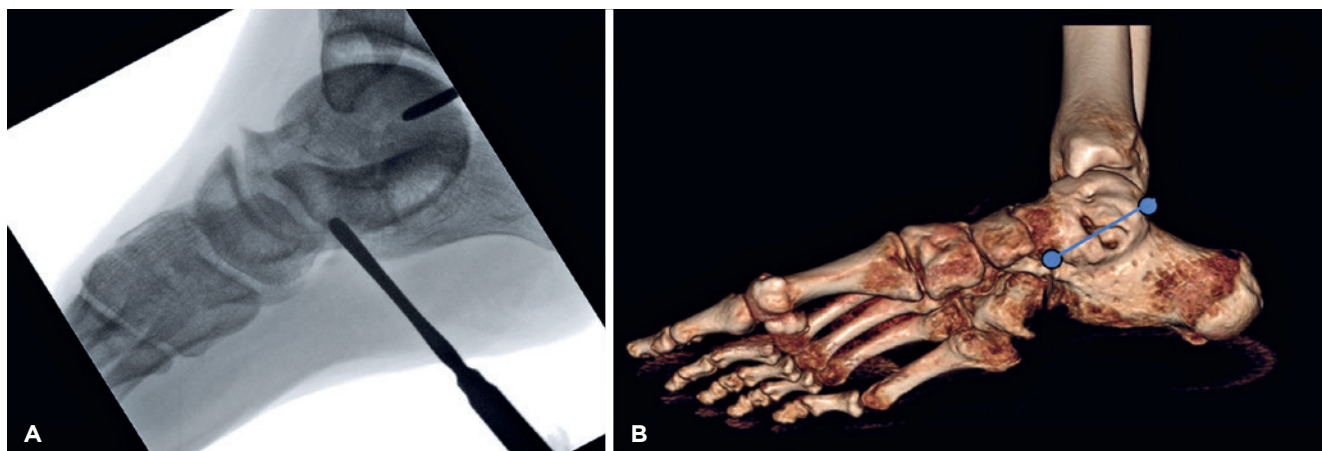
Technical tip. (A) Two Freer elevators are inserted under direct visualization to guide the orientation of the osteotomy: one in the posterolateral patent aspect of the posterior facet of the subtalar joint and one underneath the talar neck. (B) 3D Weightbearing CT bony reconstruction showing the dots representing the tip of the Freer elevators and a straight line connecting the dots, following a very similar path when considering a patent posterior facet.
